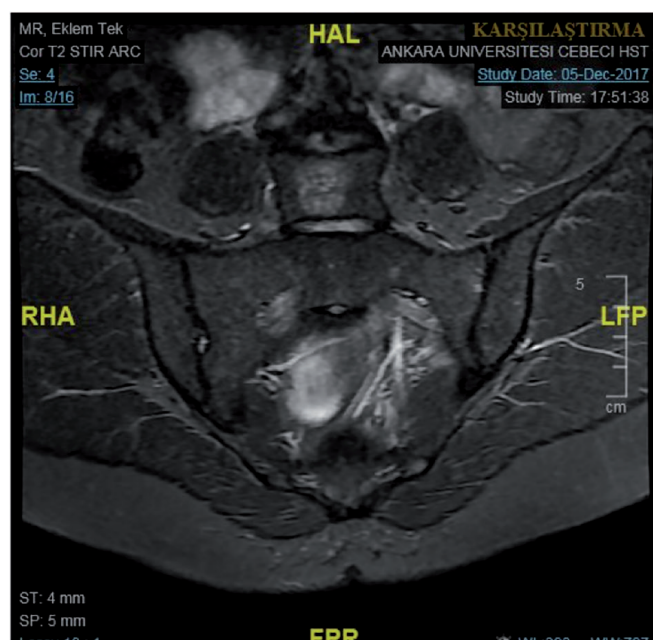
STIR coronal MRI of the sacroiliac joint, focal bone marrow edema of the left sacral facet.
